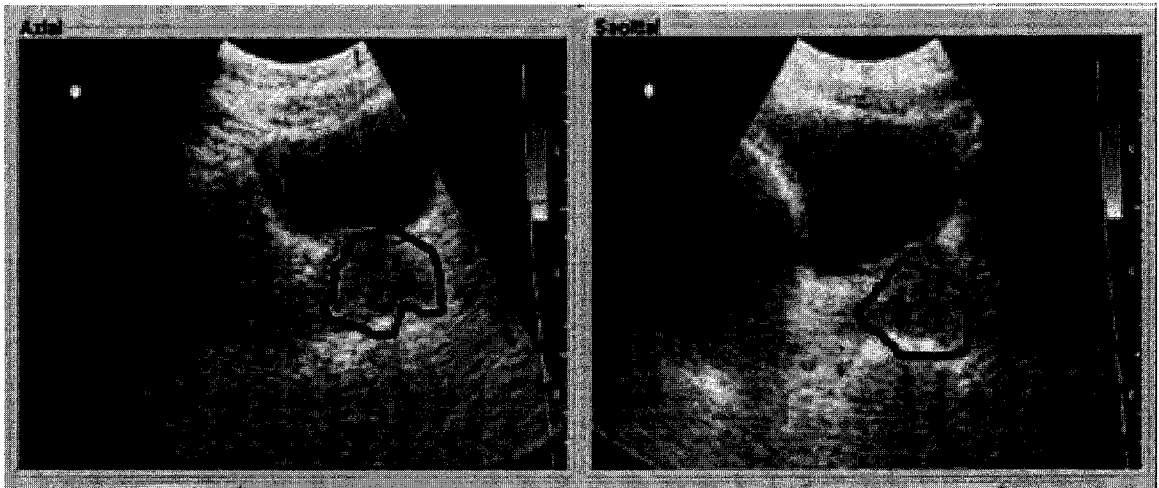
BAT US axial and sagittal images and contours used for couch alignment. The CT prostate contour is shown in heavy dark line.
